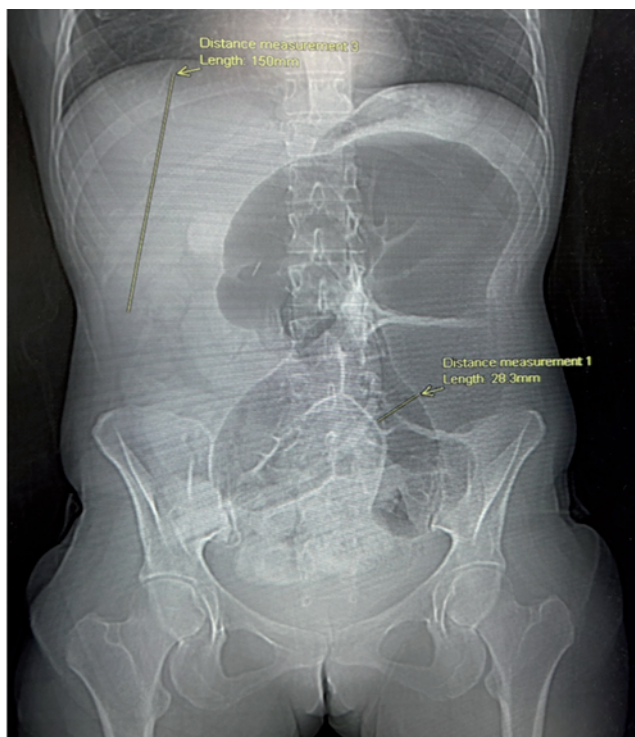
Abdominal x-ray revealed a dramatic dilation of the bowel moving upwards to the left upper quadrant of the abdomen.
